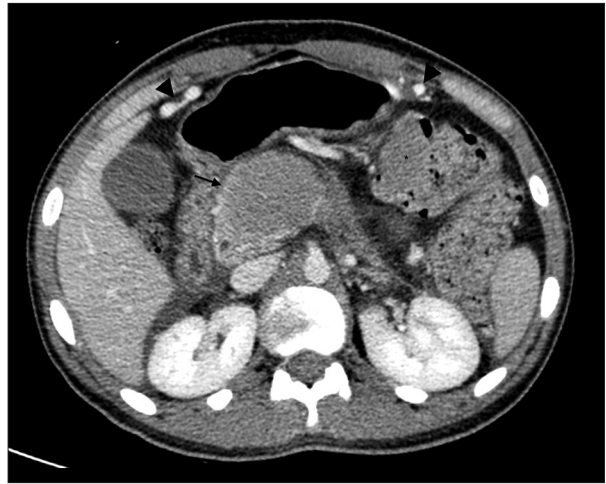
Axial CT section of the abdomen after injection of iodinated contrast medium during the portal phase. There is parietal thickening in the stomach, in addition to ulceration (arrow).
